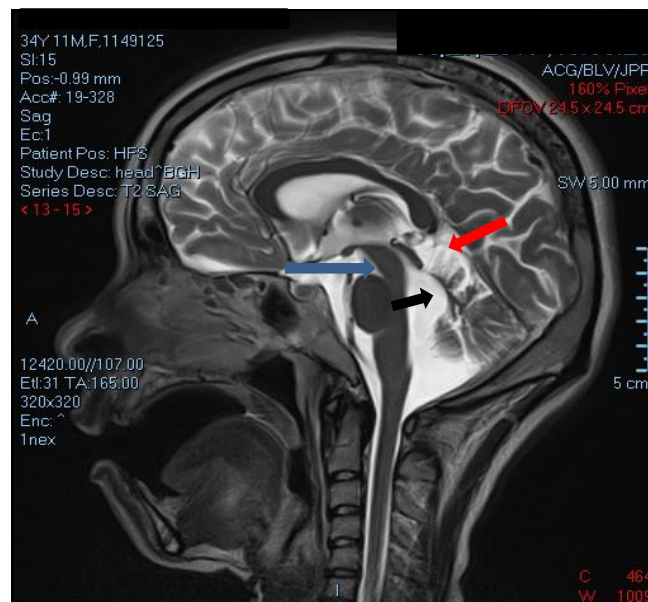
Midsagittal T2 -weighted MR image shows severe vermian hypoplasia-dysplasia (red arrow) and enlargement of the fourth ventricle with rostral shifting of fastigium (black arrow), deepened interpenduncular fossa (blue arrow)
